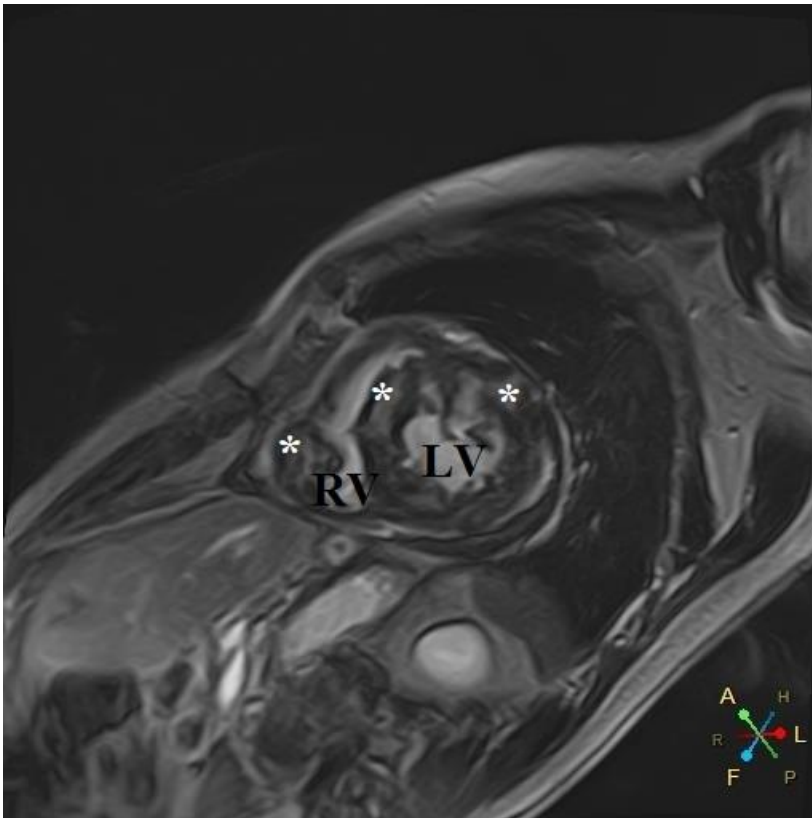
Cardiac magnetic resonance imaging - short axis view of intramyocardial masses with late gadolinium enhancement (*). LV – left ventricle, RV – right ventricle
